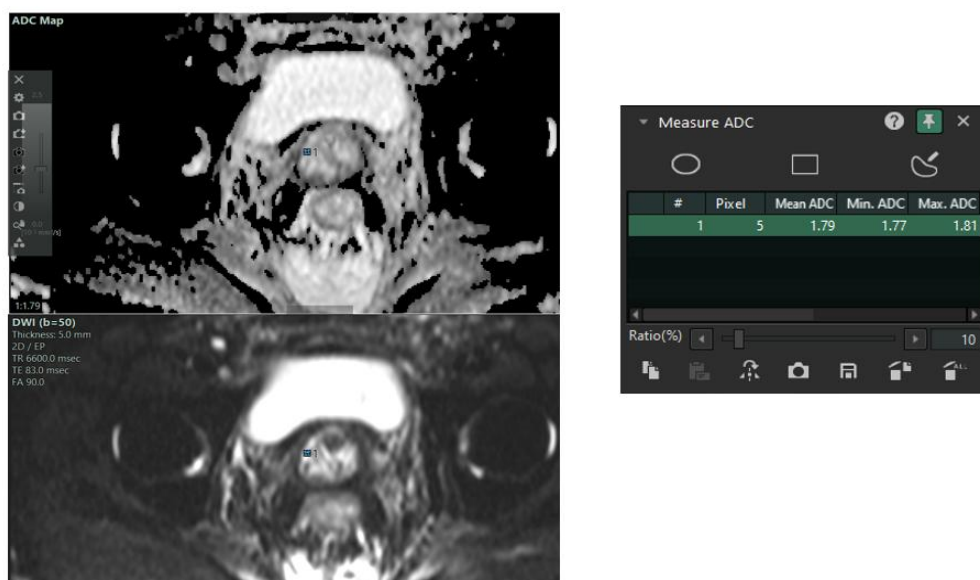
A patient with carcinoma cervix (post-treatment) shows the DWI (b=50) and corresponding ADC image in a patient with an ROI of 5 pixel (1.3 mm) showing mean ADC of 1.79.
